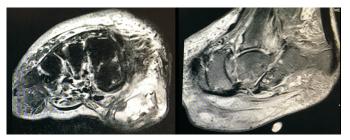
Magnetic resonance image of the mass was performed 3 years prior to presentation.
